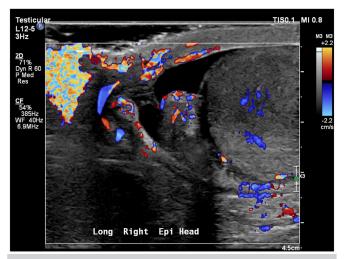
Doppler ultrasound showing perfusion of the epididymal head.
